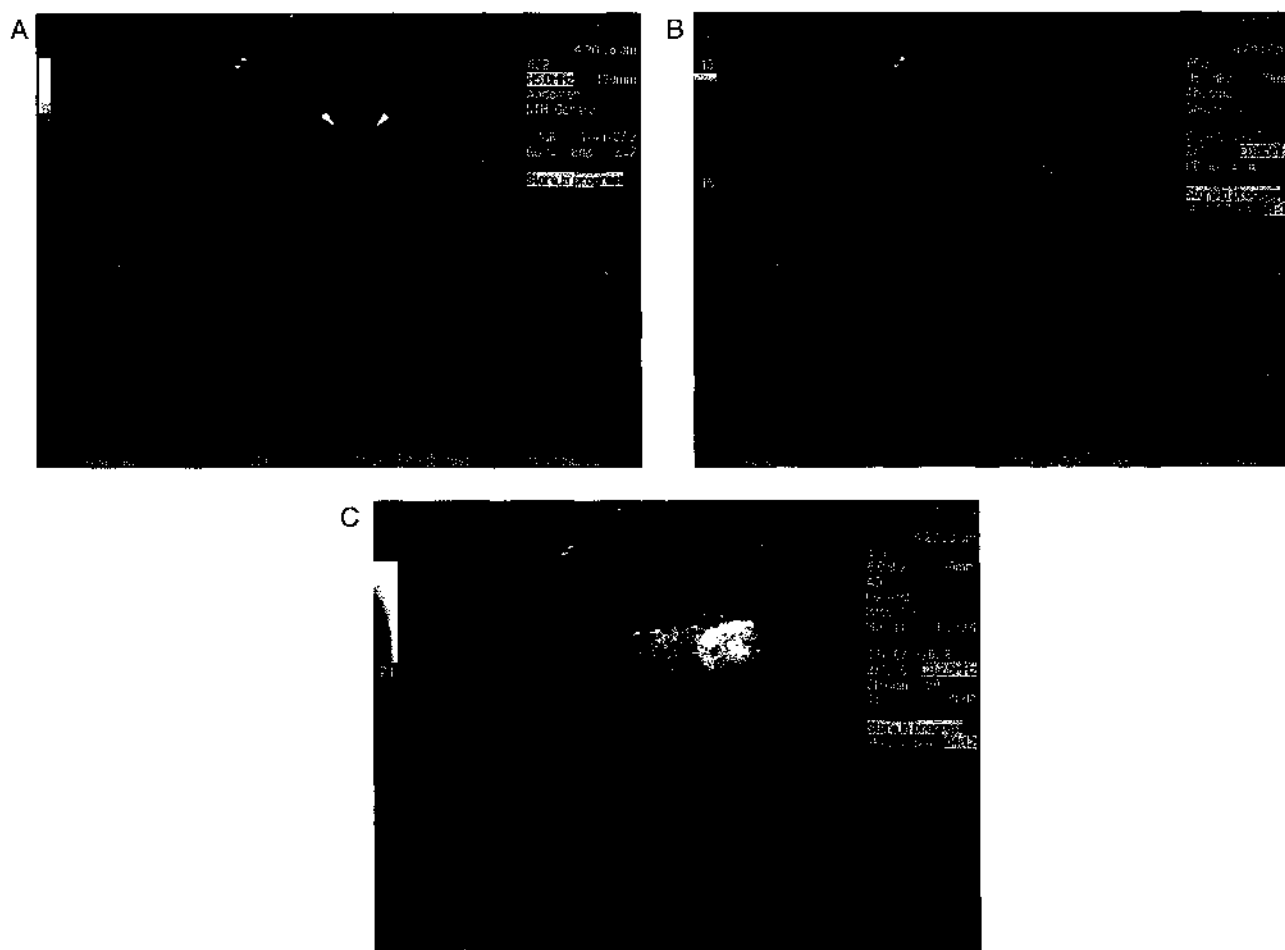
Focal nodular hyperplasia. (A) This focal lesion in the anterior part of segment 5 (arrowheads) was an incidental finding. (B) Its ill-defined margins and vascularity (color Doppler; see Plate 8) raised the suspicion of malignancy. However, following administration of the liver-specific contrast agent Levovist, nonlinear imaging shows that it takes up the agent to the same extent as the liver and it has disappeared (C). This makes the diagnosis of focal nodular hyperplasia most likely. The lesion remained unchanged a year later.
